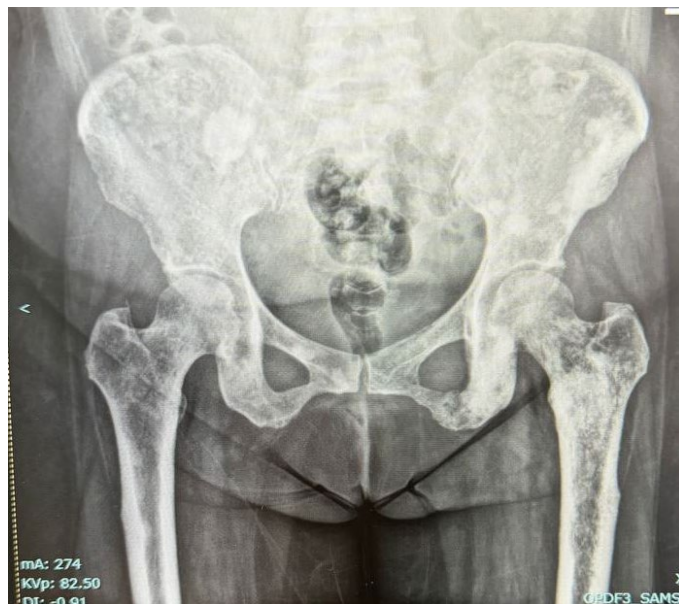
Pelvis AP X-ray noting lytic lesion on bilateral proximal femur and pelvis.
